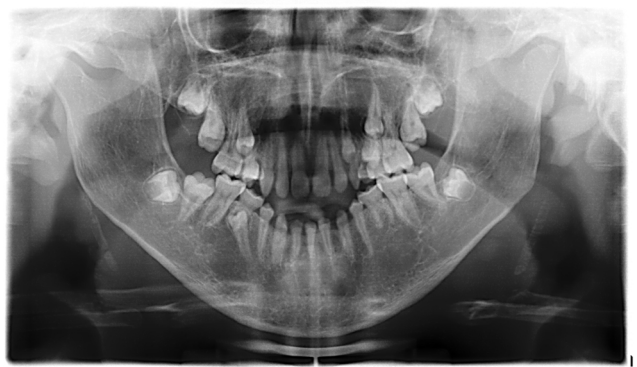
The preoperative orthopantomogram.
